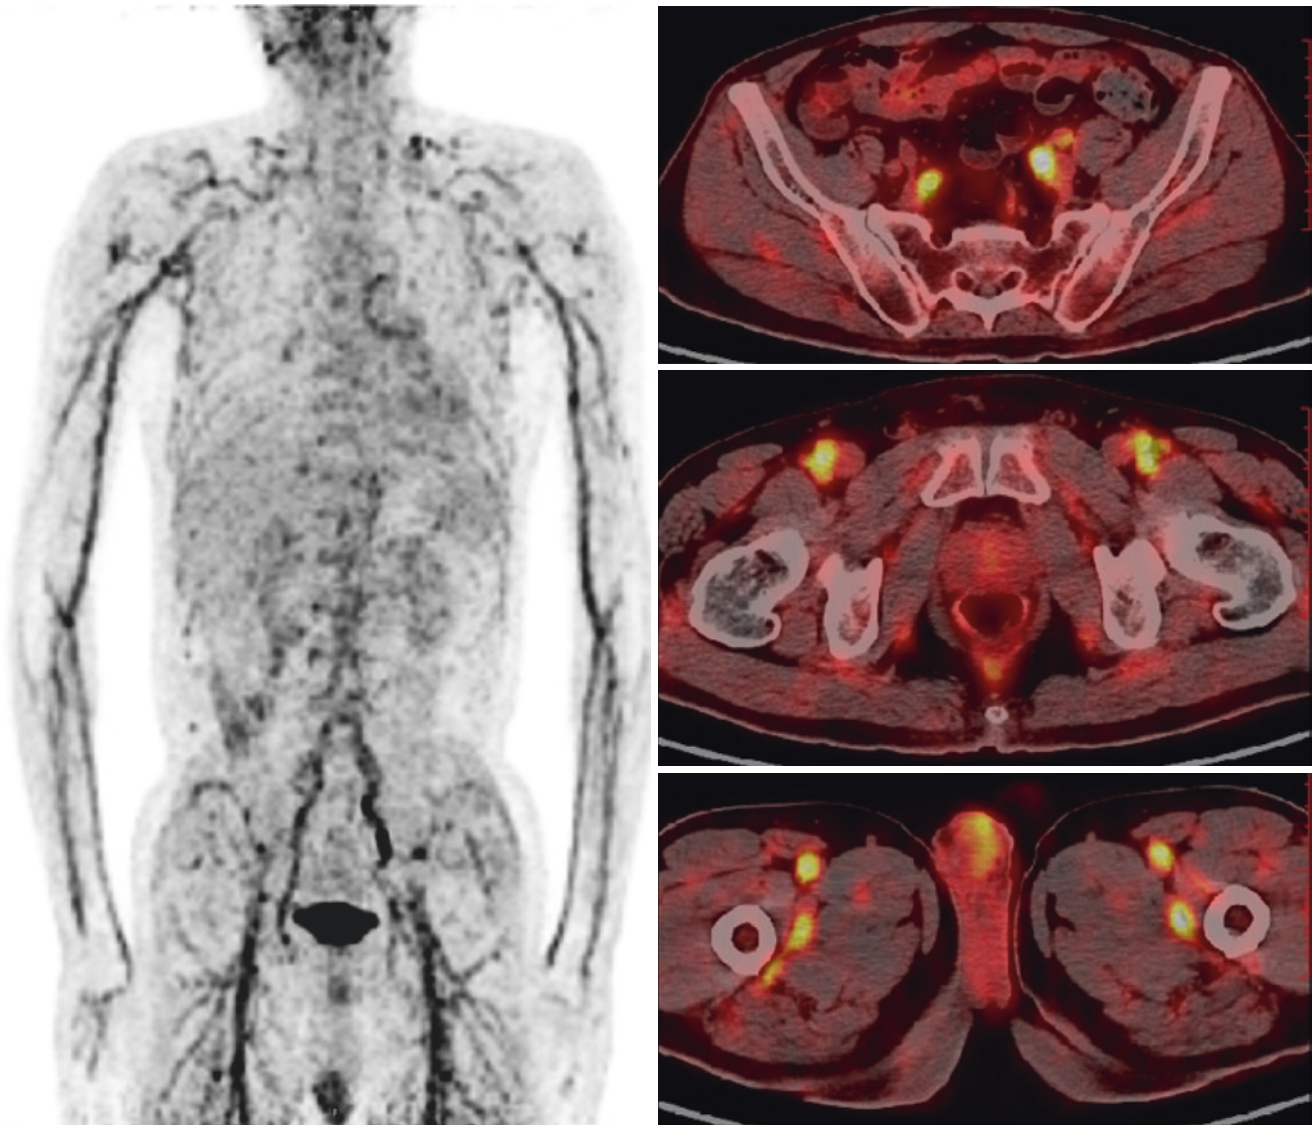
FDG PET/CT images
